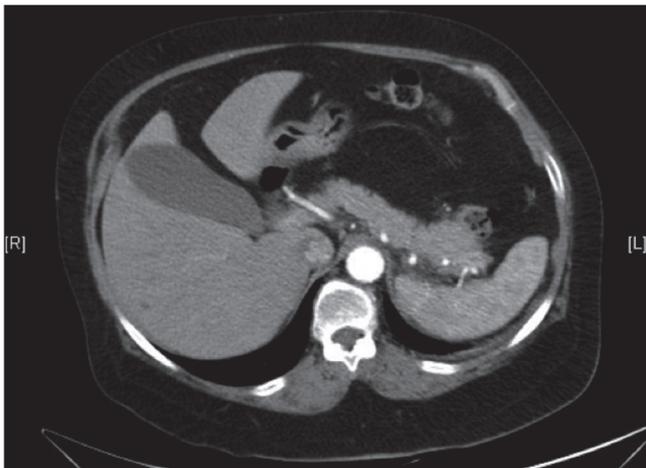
CT with intravenous contrast, axial section. The pancreas has a normal aspect with no lesions.
